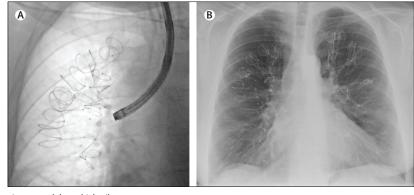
Endobronchial coils (A) Fluoroscopic image of coils placed with bronchoscopy. (B) Chest radiograph after bilateral upper-lobe treatment with coils.
